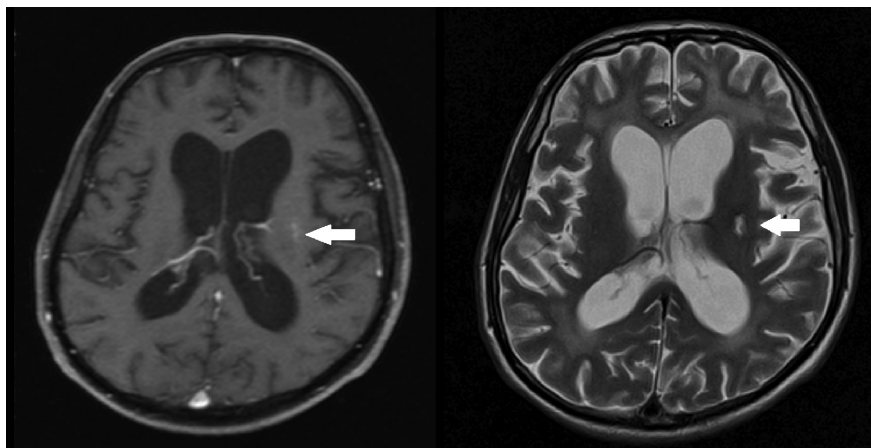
Regression and decreased contrast enhancement in the lesion in the left lentiform nucleus in post-treatment cranial magnetic resonance imaging
